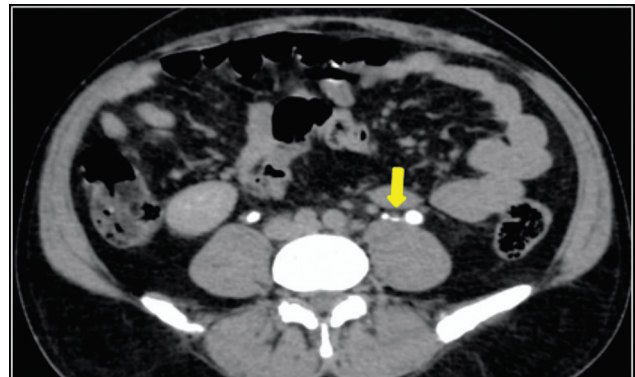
CECT-KUB (excretory phase) axial section at the level of left testicular vein crossover. CECT-KUB, contrast-enhanced computed tomography kidney, ureter, and bladder.
